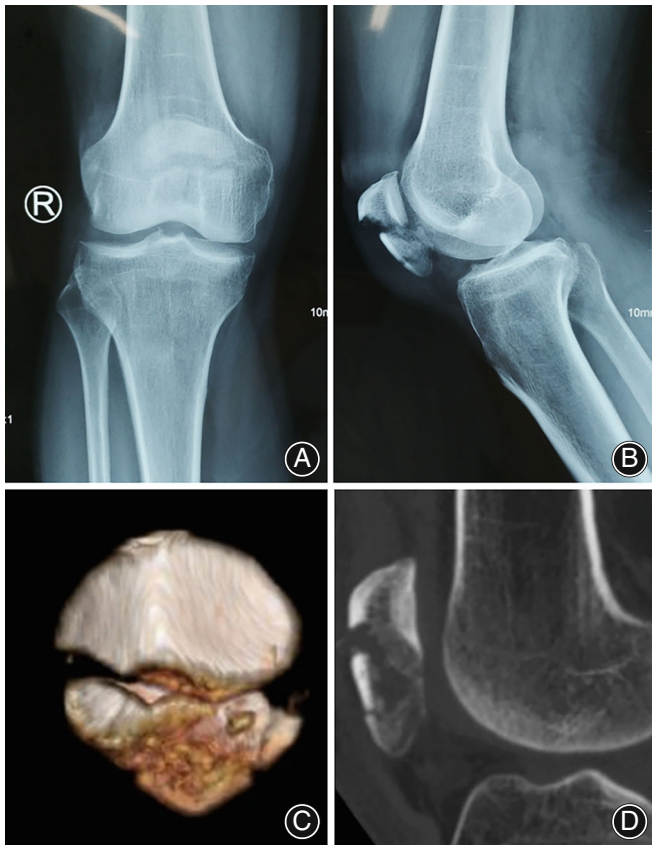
Preoperative imaging examinations of Patient 1 showing a multifragmented fracture of inferior patella pole with AO classification of C1.3; (A) Anteroposterior and (B) lateral images of X-ray examination; (C) 3D reconstruction of the patella; (D) Tomographic image in sagittal plane showing the details of distal fragments
